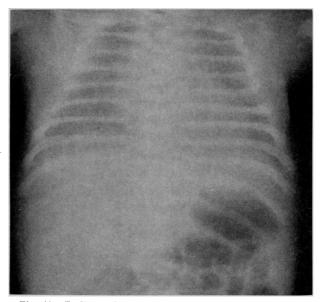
Radiograph of Baby T.B. at one day of age showing the typical generalized opacity of the lung fields in severe respiratory distress syndome.
